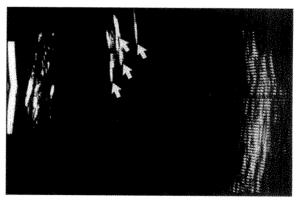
(Whitacre). Immediately after pneumatic retinopexy multiple bubbles (resembling fish eggs) were present, which produced multiple echoes (arrows). The unequal spacing between the echoes proves that the echoes are not reverberations from a single source. The patient's head was erect and the ultrasound probe was in line with the visual axis.
